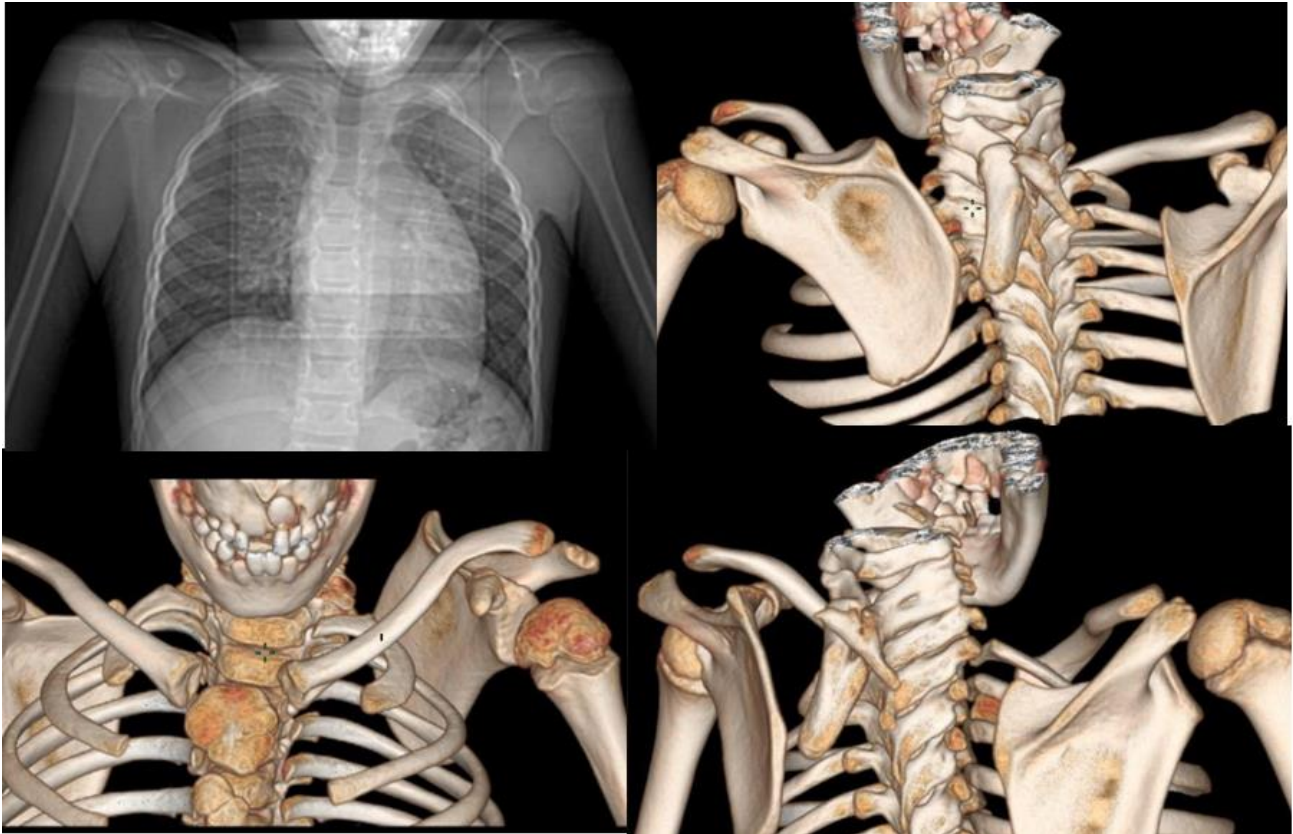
CT images in VR reconstruction showing elevation of the left scapula with its superior-internal border located opposite to C6 and an omo-vertebral bone connecting C5 to the medial border of the scapula
